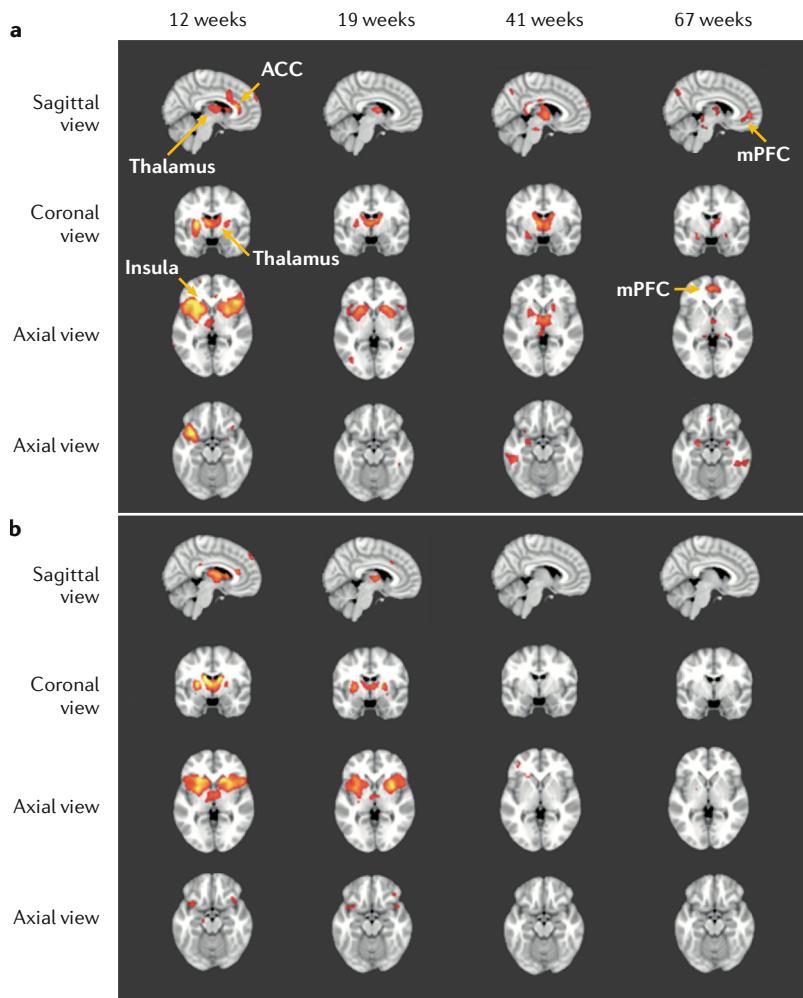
Changes in brain activity underlying the transition from acute to chronic back pain. Brain scans using functional MRI during early visits (12 weeks and 19 weeks) past pain onset show activation in brain regions commonly engaged during acute pain (such as the thalamus, anterior cingulate cortex (ACC) and insula). After ~1 year, significant activation differences among those who developed chronic pain (panel a) and those who did not (panel b) were found in the medial prefrontal cortex (mPFC) more closely linked to self-referential and emotional processing in the amygdala. Activation clusters are shown using a colour scale ranging from red (lower activation) to yellow (higher activation). The time points refer to the average duration past pain onset. Adapted with permission from REF.⁷⁷, Oxford University Press.
